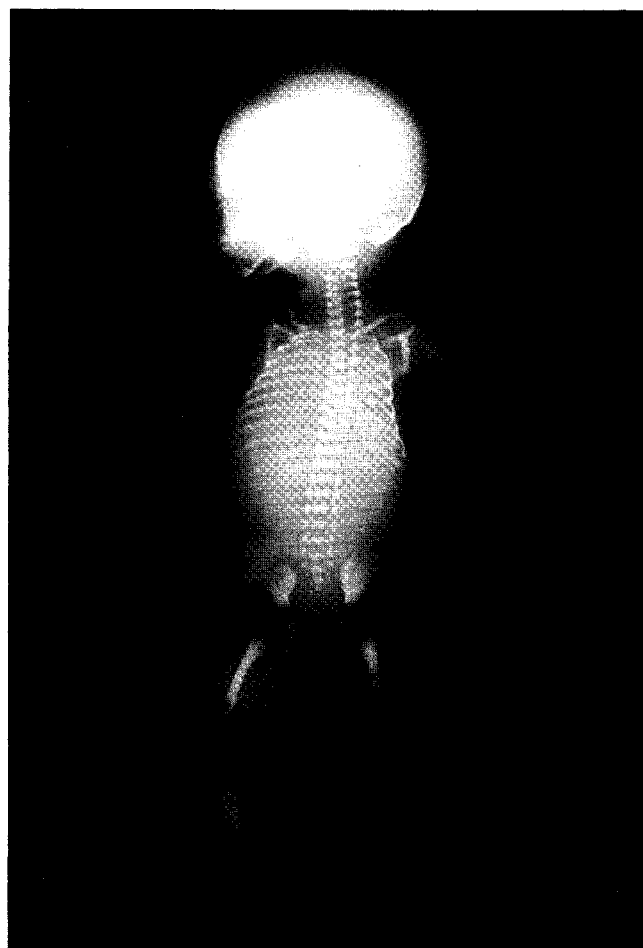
X-ray: soft tissue hypertrophy of right leg, without apparent bony hypertrophy
